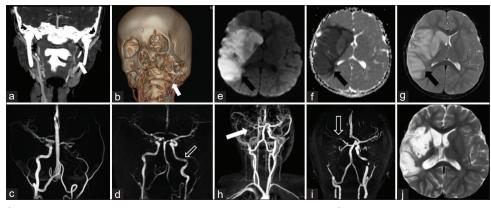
Patient 13: CTA (a) shows the presence of peripheral thrombus and stenosis of the left ICA cervical segment due to dissection. Volume-rendered 3D images (b) demonstrate the presence of the elongated styloid process (Eagle syndrome). While the initial MRA (c) revealed the occlusion of the left ICA, the follow-up MRI (d) showed the resolution of the left ICA occlusion. Patient 15: DWI image (e), ADC map (f), and T2WI (g) demonstrate diffusion restriction corresponding to the acute infarction in the right MCA territory (black arrows). MRA (h) shows occlusion of the right ICA and MCA due to dissection (White arrow). Follow-up MRA 1 year later (i) shows persistent right ICA occlusion that has not developed recanalization and the retrograde opacification of the MCA M1 segment via the right PCA (open arrow). Also, follow-up MRIs (j) demonstrate chronic encephalomalacia
